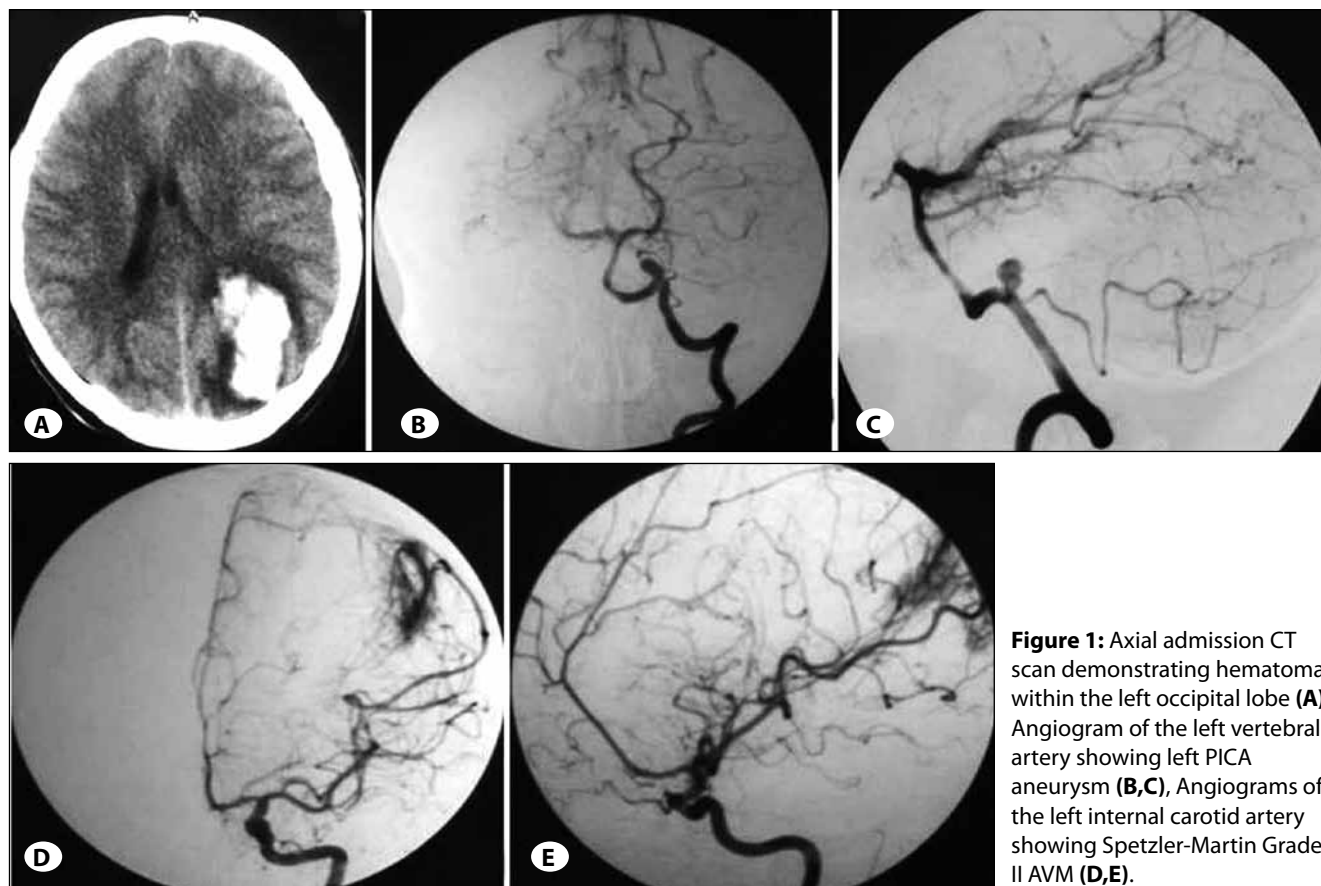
Axial admission CT scan demonstrating hematoma within the left occipital lobe (A), Angiogram of the left vertebral artery showing left PICA aneurysm (B,C), Angiograms of the left internal carotid artery showing Spetzler-Martin Grade II AVM (D,E).
